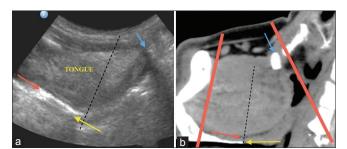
(a) Midsagittal section (step 3). Two parallel echogenic lines are seen at dorsum of tongue, inner representing the air-mucosal interface tongue and outer representing hard palate with posterior acoustic shadowing. Dotted black dividing tongue into anterior and posterior halves. (b) Corresponding computed tomographic section (red lines – representing limit of ultrasound scan extent); blue arrow, body of hyoid; red arrow, inner echogenic line; yellow arrow, outer echogenic line; dotted black line, imaginary line perpendicular to the axis of palate
